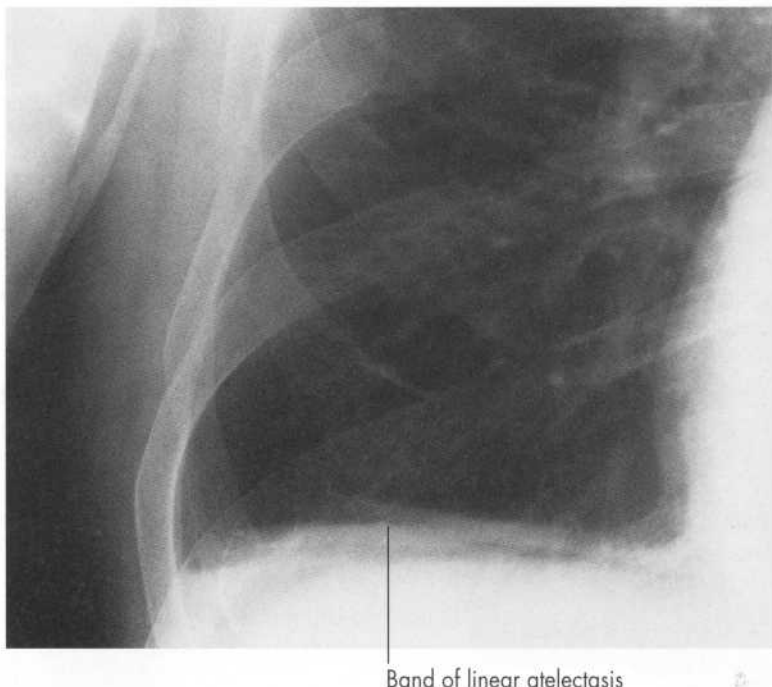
This is a postoperative general anaesthetic patient who has just had ENT surgery. Detail from right base of a chest X-ray.
